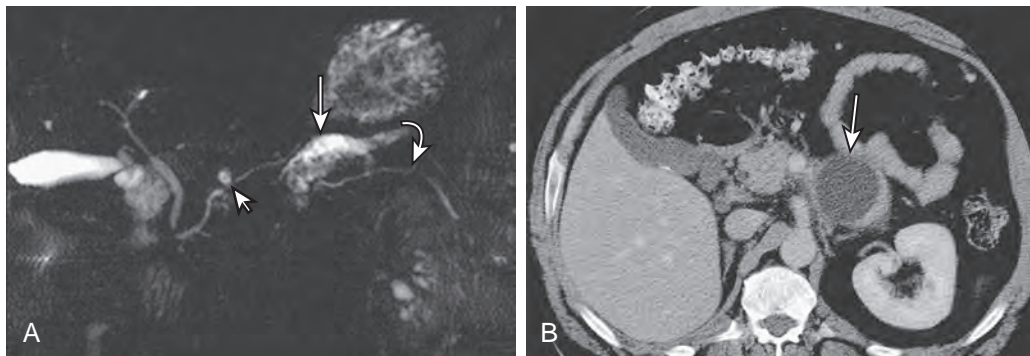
Pancreatic duct injury and subsequent pseudocyst formation. The initial CT scan showed no abnormality in the pancreas, but the patient returned with severe abdominal pain. A. Thick-slab rapid acquisition and relaxation enhancement (RARE) MRCP image shows the disrupted duct (short arrow) and the resulting peripancreatic fluid collection (long arrow). Note how it is feasible with MRCP to evaluate the pancreatic duct distal to the site of injury and extravasation (curved arrow). B. Short-term follow-up axial MDCT scan shows a more organized pancreatic pseudocyst (arrow), which was subsequently successfully drained.
